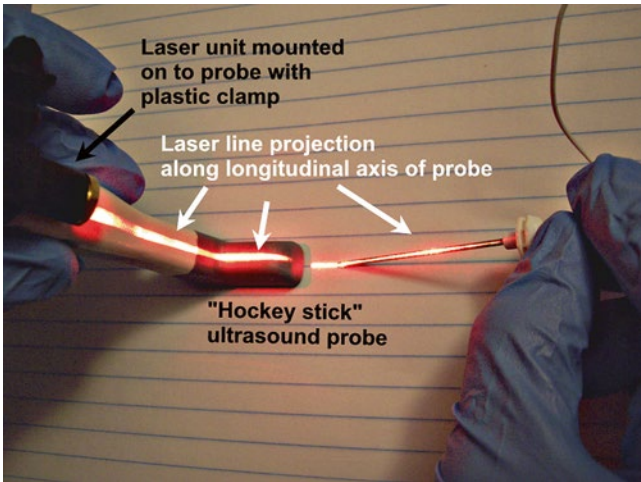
Alignment of the block needle and ultrasound beam using a laser line (Reprinted from Tsui [3]. With permission from Wolters Kluwer Health)
